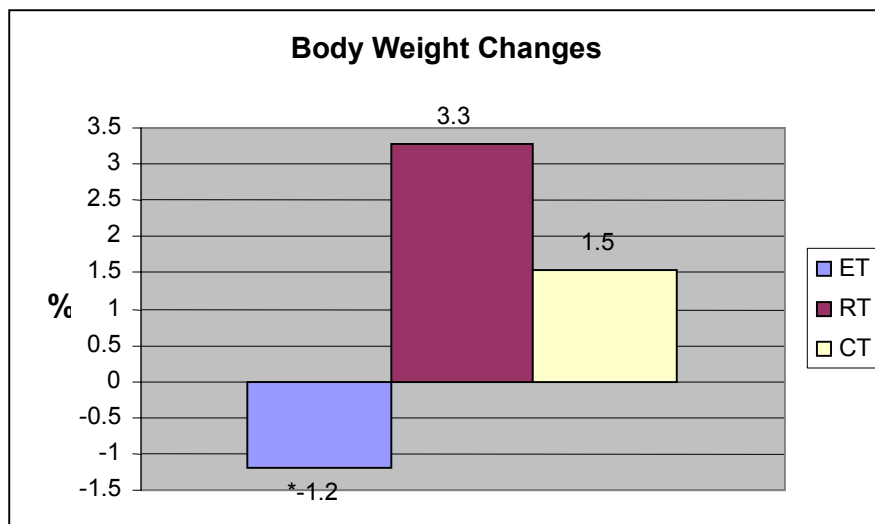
Percent body weight changes form pre- to post-training. \* Significantly different from RT and CT changes. ( $P \leq .05$ )
